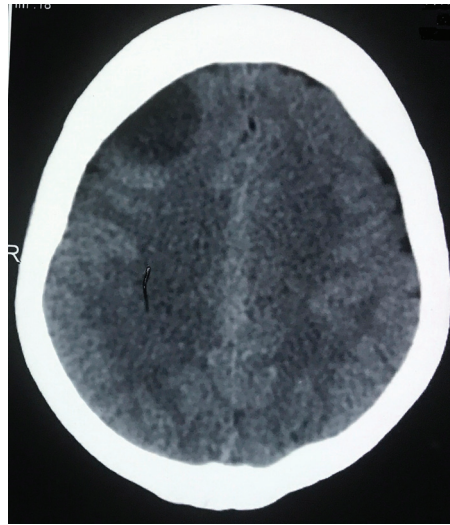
Plain computed tomography head showing hypodensity in right frontal lobe.
